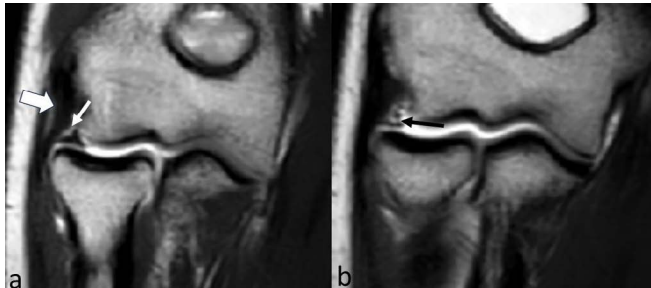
Coronal T1-weighted images: RCL fibrous thickening (white big arrow) and meniscus homologous tear (white arrow in “a” and black arrow in “b”).
